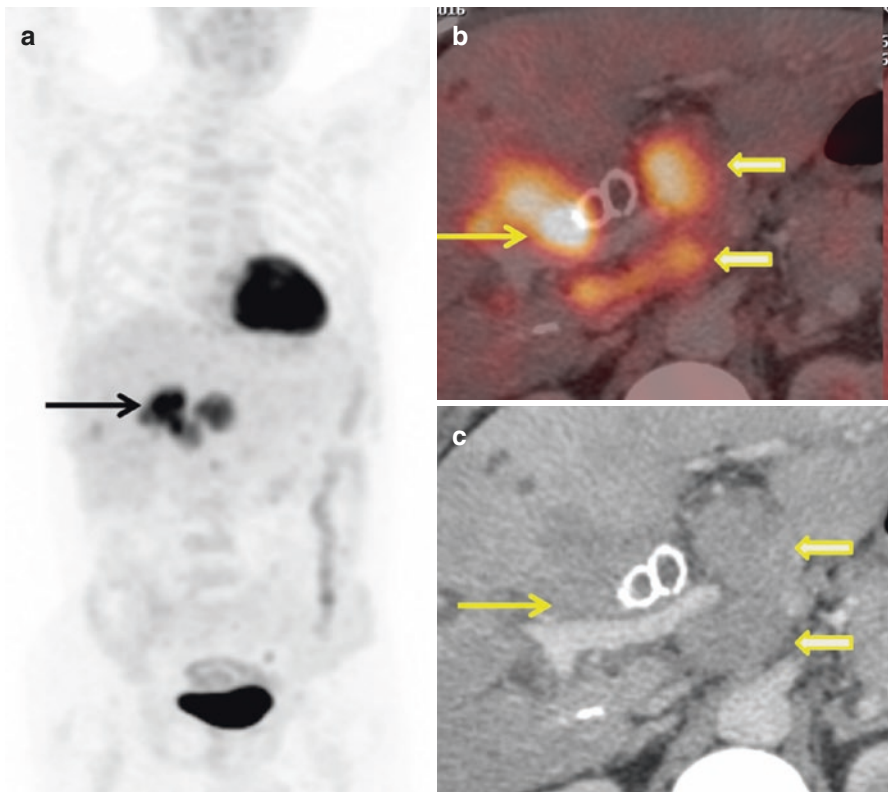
^{18}F -FDG PET/CT study of a male patient, 57 years, a case of cholangiocarcinoma. Hypermetabolic mass is seen at the hilar confluence (*arrow* a–c) (maxSUV 10.38) with multiple enlarged periportal lymph nodes (*block arrow*) (maxSUV 8.1)
